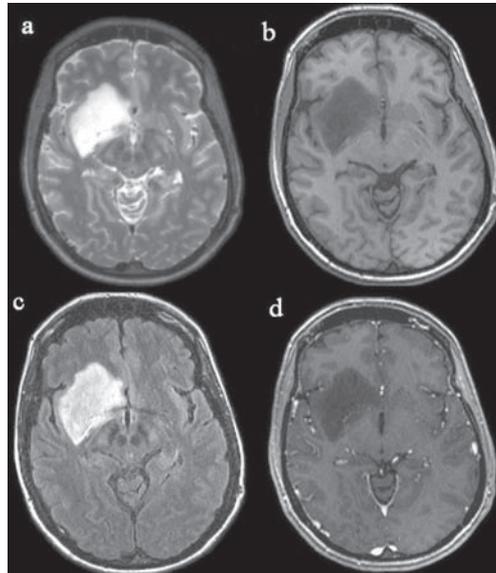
Low-grade glioma. Axial T2-weighted image (a) demonstrates a homogeneously hyperintense mass in the insular region extending into the right frontal lobe. This mass is well circumscribed with minimal mass effect and edema that appears hypointense on T1-weighted image (b) and hyperintense on FLAIR image (c). There is no evidence of abnormal contrast enhancement on the post contrast T1-weighted image (d)
